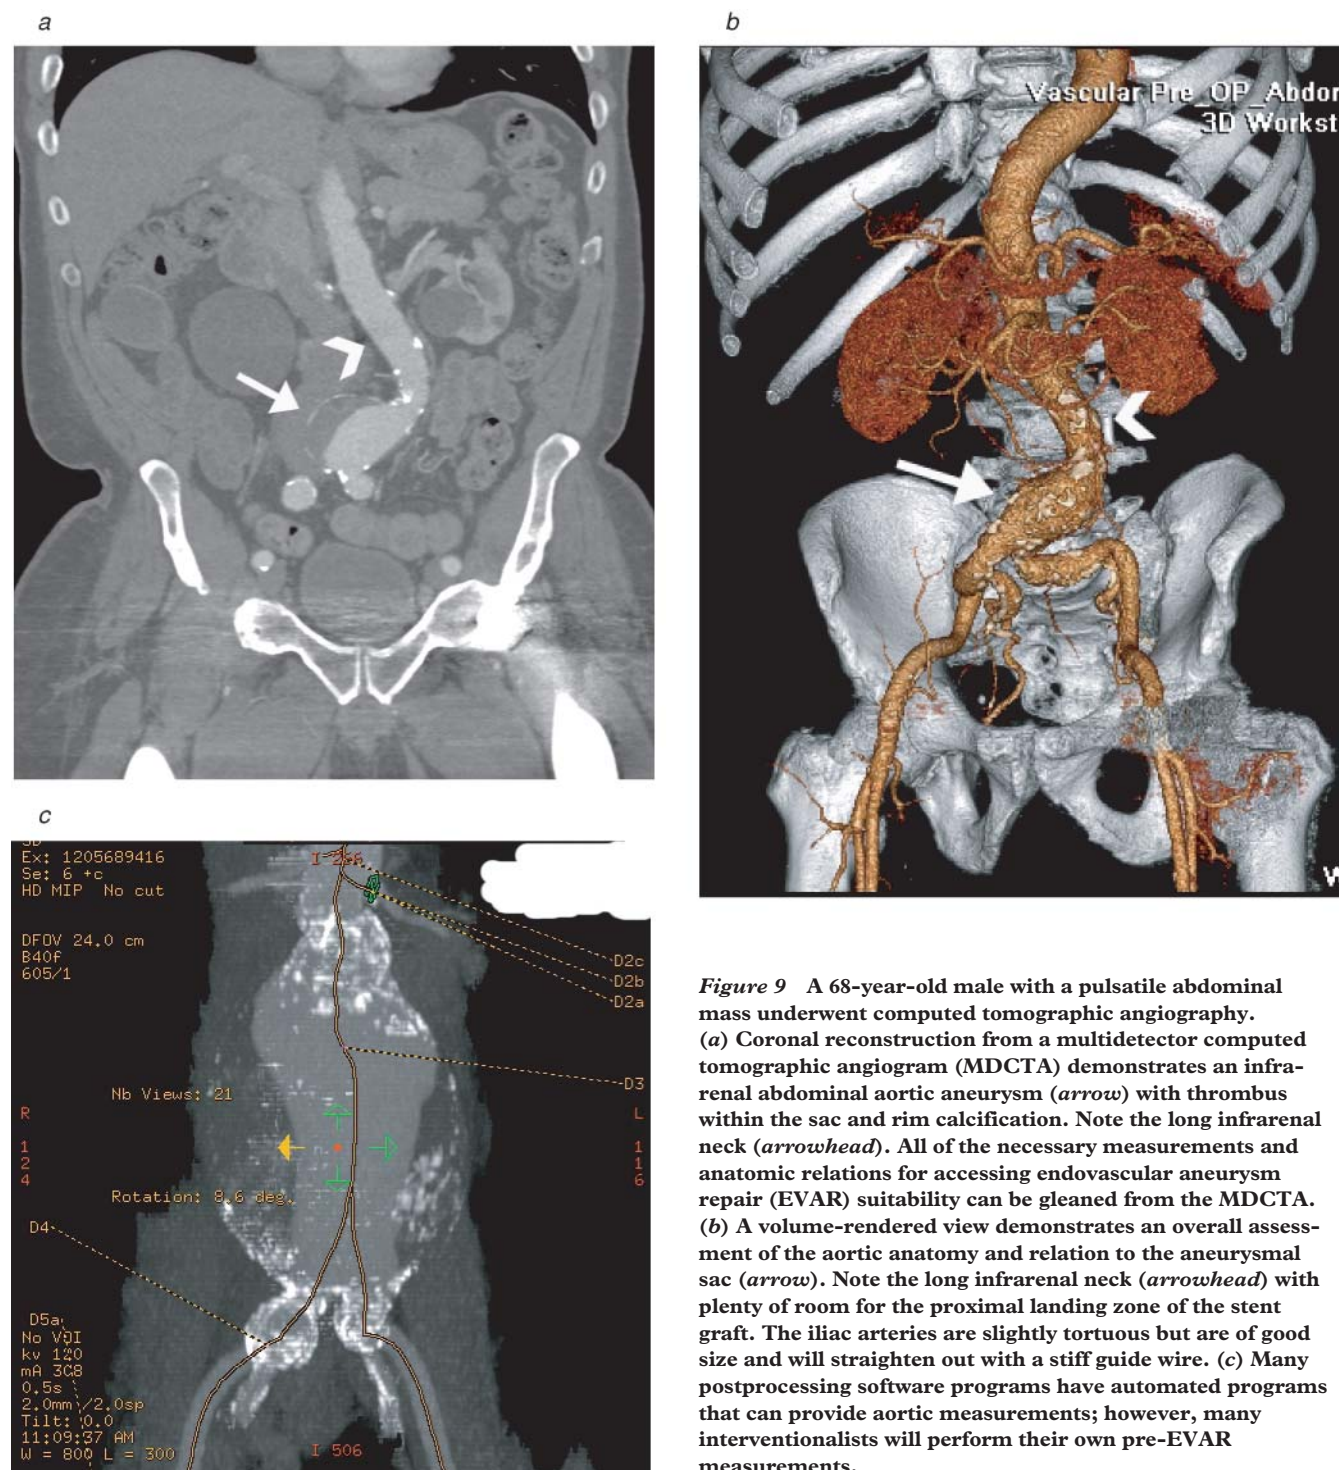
A 68-year-old male with a pulsatile abdominal mass underwent computed tomographic angiography. (a) Coronal reconstruction from a multidetector computed tomographic angiogram (MDCTA) demonstrates an infrarenal abdominal aortic aneurysm (arrow) with thrombus within the sac and rim calcification. Note the long infrarenal neck (arrowhead). All of the necessary measurements and anatomic relations for accessing endovascular aneurysm repair (EVAR) suitability can be gleaned from the MDCTA. (b) A volume-rendered view demonstrates an overall assessment of the aortic anatomy and relation to the aneurysmal sac (arrow). Note the long infrarenal neck (arrowhead) with plenty of room for the proximal landing zone of the stent graft. The iliac arteries are slightly tortuous but are of good size and will straighten out with a stiff guide wire. (c) Many postprocessing software programs have automated programs that can provide aortic measurements; however, many interventionalists will perform their own pre-EVAR measurements.
